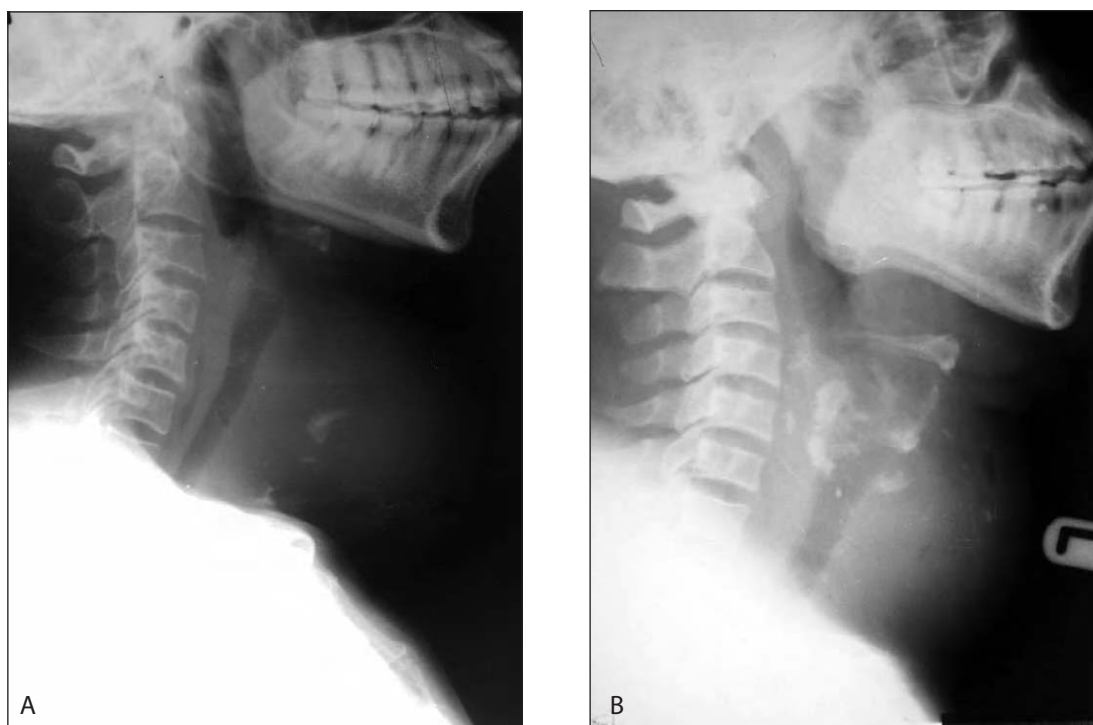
Lateral neck radiographs showing mixed calcifications (nodular and flat). Note tracheal narrowing and air oesophagogram in [A]
